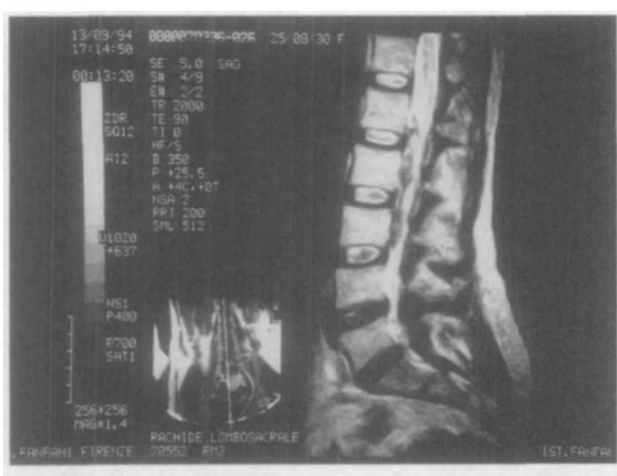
FIGURE MRI scan: Fusijam swelling anterior to the cord.
